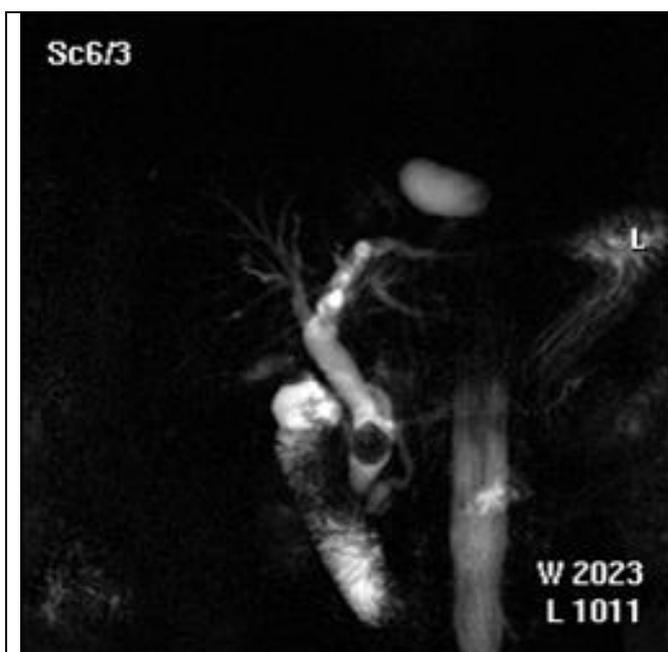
MR – cholangiography. Capabilities MRI are similar with those of CT, but at MRI image can be obtained in all shots, it is possible to obtain the image of hepatic vessels (MR - angiography), bile ducts and pancreatic ducts (MR - cholangiography).
